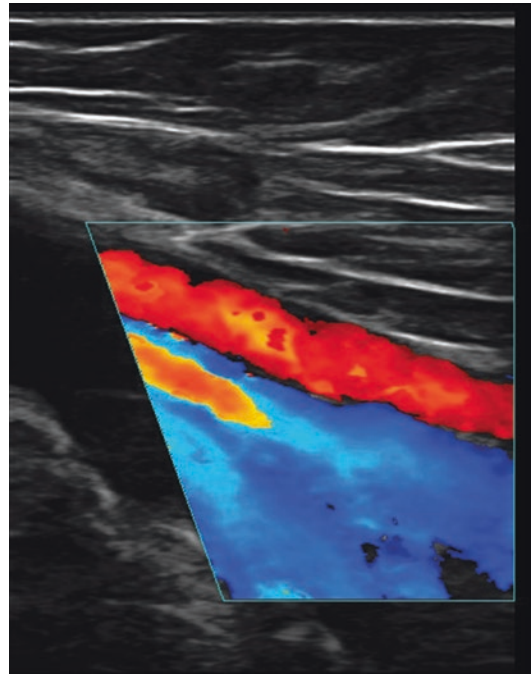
This 57-year-old woman underwent color Doppler imaging (*above*) and Doppler waveform analysis (*below*) of the right common femoral vein 1 week after liposuction of the arms and axillae and brachioplasties. The distal thigh is compressed, causing a spike proximally at the level of the transducer in the right common femoral vein (shown as a “Z”, *above*), which indicates blood flow.
